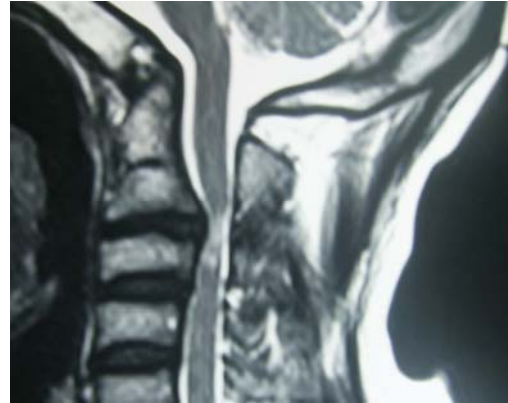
Sagittal T2 weighted MRI showing central disc herniation at C2-C3 level with significant canal compression and T2 hyperintense signal changes in the cord.
